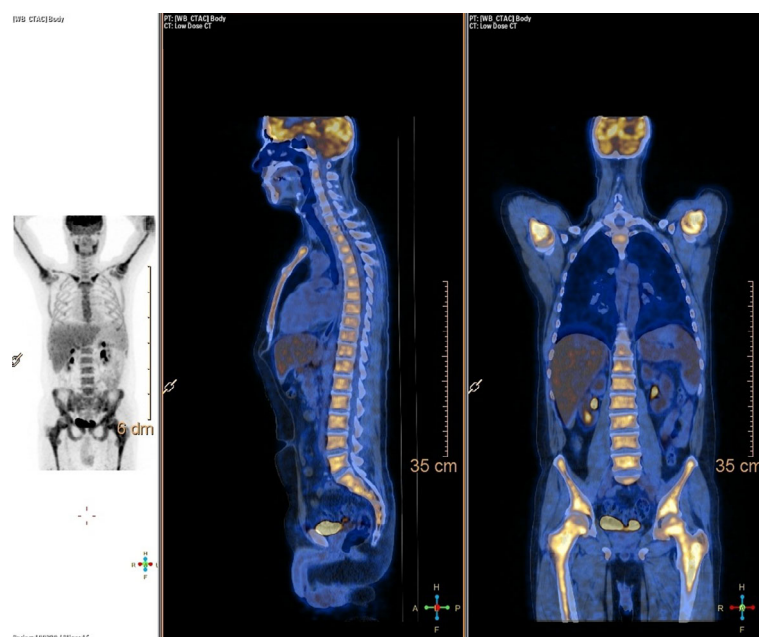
On PET/CT images bone marrow has diffuse increased uptake with a standardized uptake value (SUVmax value) of 8 at the caput of femur. Liver to spleen ratio is in normal limits. Scanning of the lower limb shows that increased metabolic activity of bone marrow also includes appendicular skeletal system. There are no pathological lymph nodes in the body. Lung parenchyma and abdominal organs have normal findings. Bone marrow also includes appendicular skeletal system. There are no pathological lymph nodes in the body. Lung parenchyma and abdominal organs have normal findings.
